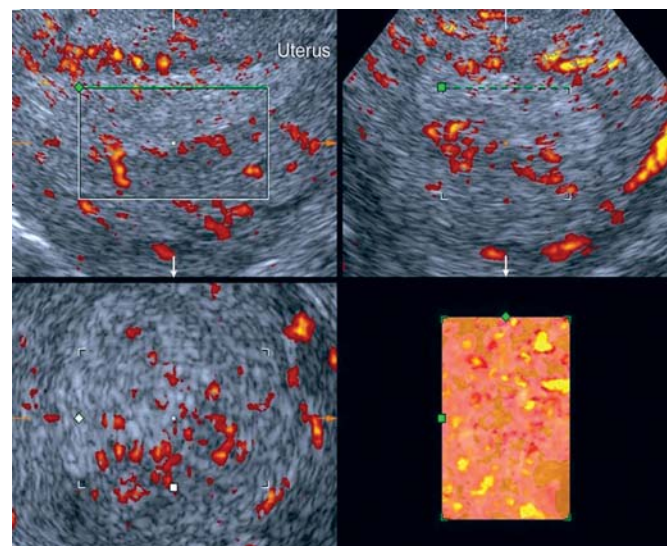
3D acquisition can be obtained simultaneously in grey scale and color Doppler/power Doppler modes. These may be zoomed in for better visualization
